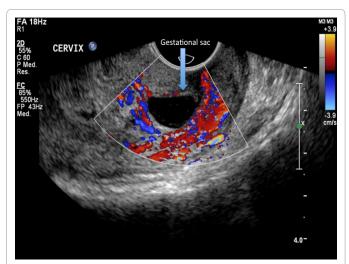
Doppler ultrasonography helps identify the intense vascular reaction surrounding the gestational sac in uterine cervix, revealing the active decidual reaction.
